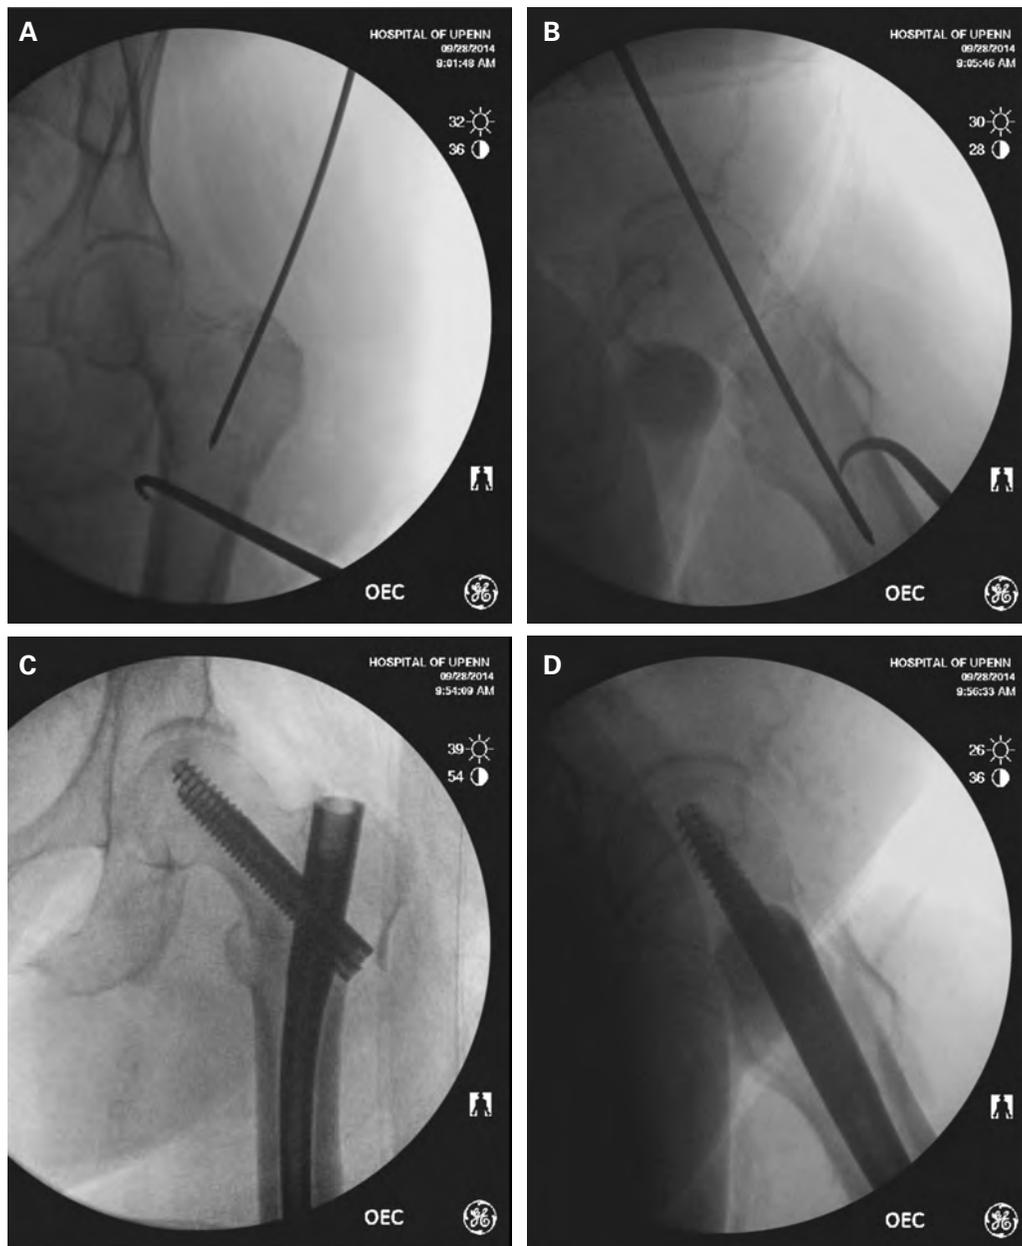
Fracture reduction held with intramedullary fixation being placed on AP (A) and lateral (B) radiographs; Final AP (C) and lateral (D) radiographs after cephalomedullary fixation.
